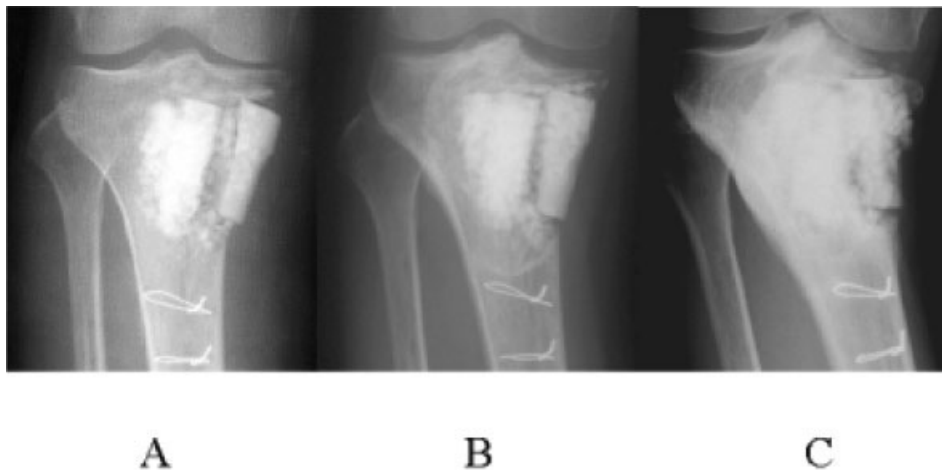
Radiographs of a simple bone cyst in a 9-year-old male (Case 1-6). (A) Immediate post-operative radiograph displaying granules of HA and surrounding radiolucent zone. (B) The radiolucent zone was present after 8 weeks. (C) The radiolucent zone vanished after 16 weeks. (D) One hundred eleven months later, increased radiographic density at HA implant sites and diminished discrimination between HA blocks or granules were apparent. However, no obvious evidence of biodegradation was detected.
